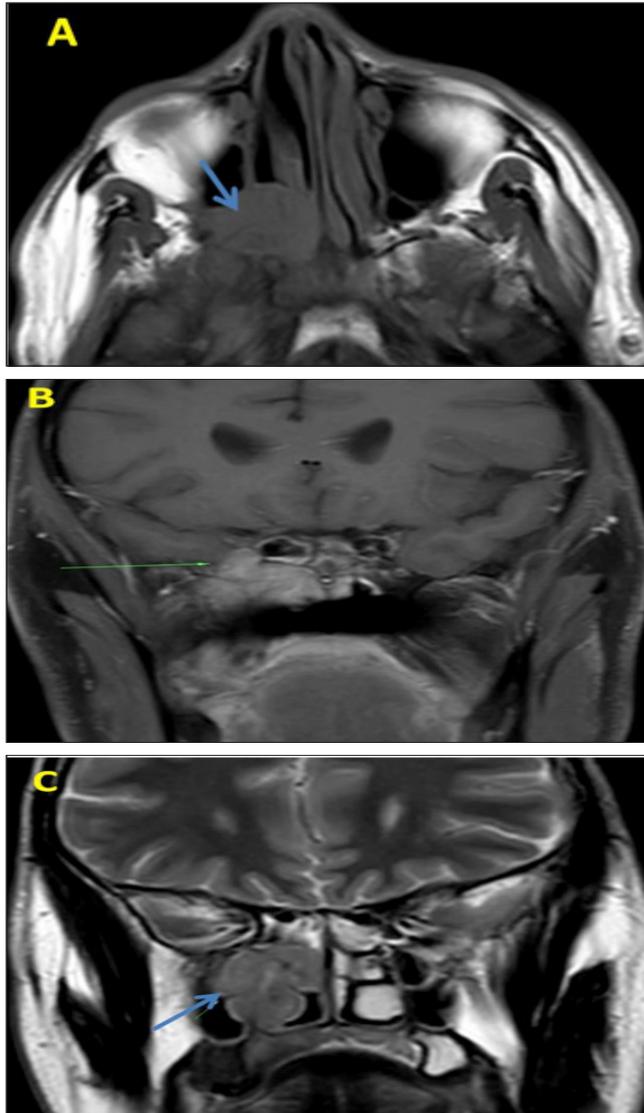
MRI in T1 axial section (A) and T1 Gado sequence in coronal section (B), T2 coronal section (C) showing an infiltrative tumor process (thick arrow) centered on the right pterygo-palatine fossa which is in discrete hyposignal T1, hypersignal T2 intensely enhanced after injection of gadolinium, with endocranial extension (Thin arrow)
